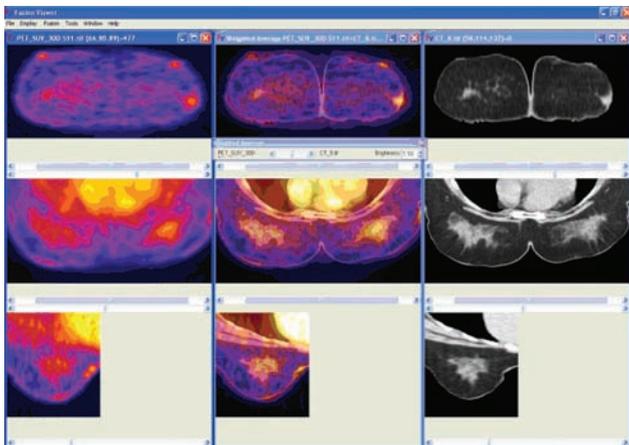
Left: The three orthogonal images are from the PET data set after the application of the Fire color table. Right: Three orthogonal images from the CT data set. Center: Three orthogonal images in the center from fusing the PET and CT images using the weighted average fusion plug-in. Not only can we see the anatomical structure, but we can also see the metabolic activity for each structure.
